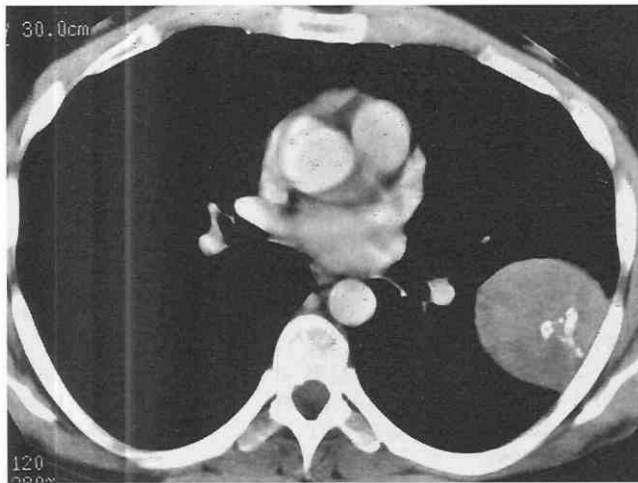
Benign pleural fibroma. Enhanced CT scan reveals a soft tissue intrafissural mass with coarse calcifications, pathologically consistent with a benign pleural fibroma. (From Knisely BL, Kuhlman JE: Radiographic and CT imaging of complex pleural disease. *Crit Rev Diagn Imaging* 38:1, 1997.)
